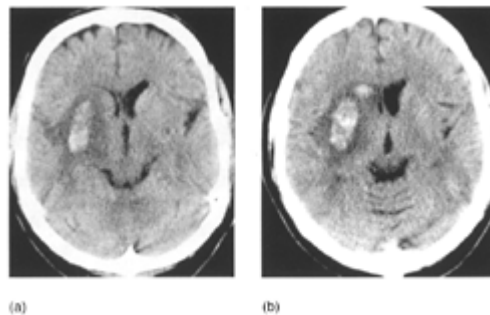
CT of the same patient as in Figs. 5.4 and 5.5 obtained 4 days after stroke onset and after local thrombolysis with 20 mg recombinant tissue plasminogen activator (rt-PA).
